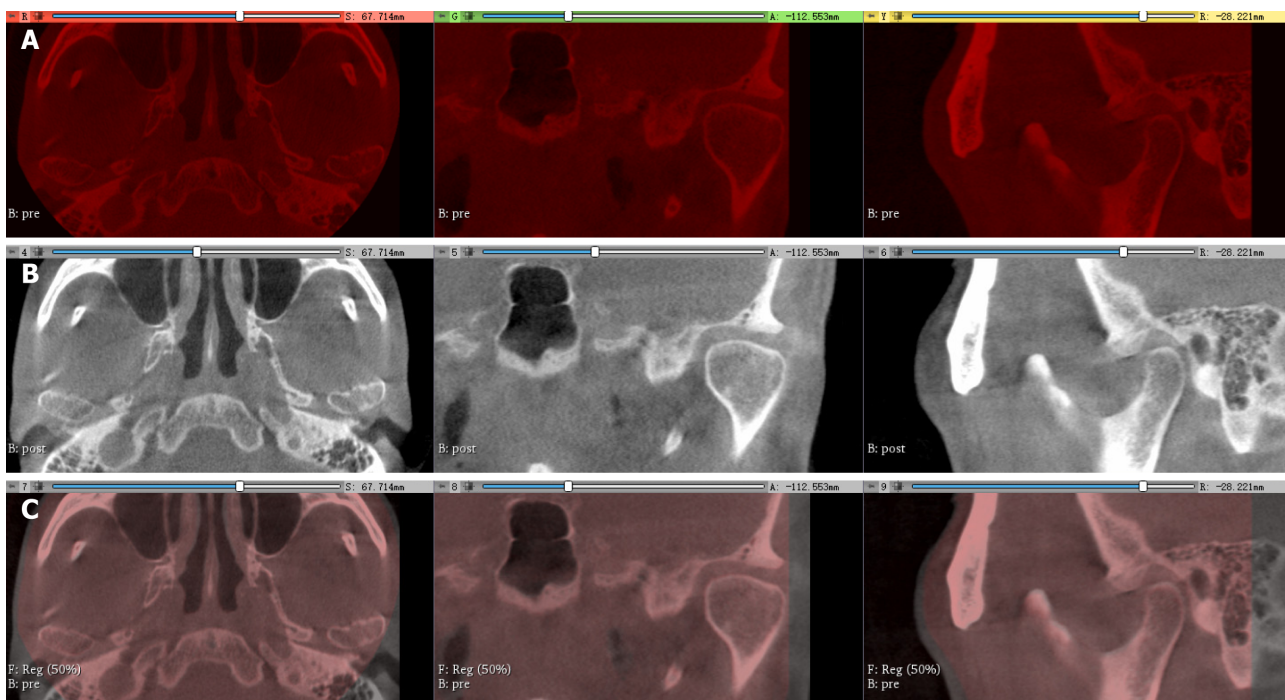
Registration of the pre- and post-cone-beam computed tomography images. A: Cone-beam computed tomography (CBCT) images pre-treatment are labeled red; B: Seven-year follow-up CBCT images post-treatment are labeled gray; C: General registration was performed to superimpose the pre-CBCT and post-CBCT images. Pre-CBCT images served as fixed images with a 50% transparency while post-CBCT images as moving images. A perfect match of the whole images revealed no significant longitudinal changes of the temporomandibular joint.
